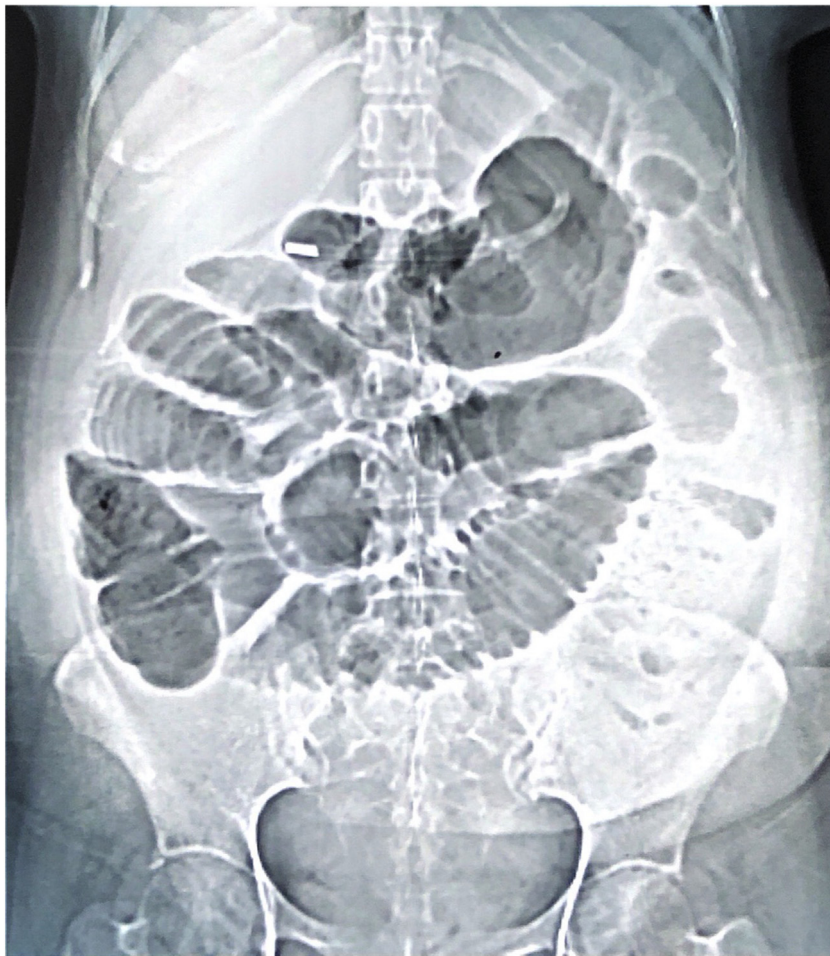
Simple abdominal radiograph showing signs suggestive of intestinal obstruction.
